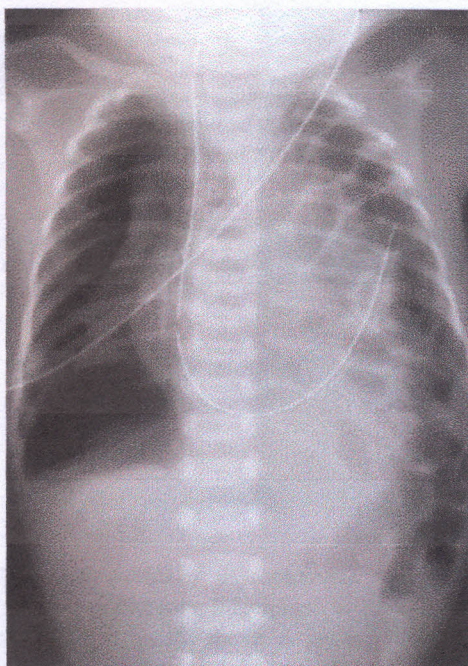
A 1-hour-old infant with a large left Bochdalek hernia and right-side tension pneumothorax. Chest radiograph shows minimal mediastinal displacement by herniated bowel in the left chest
